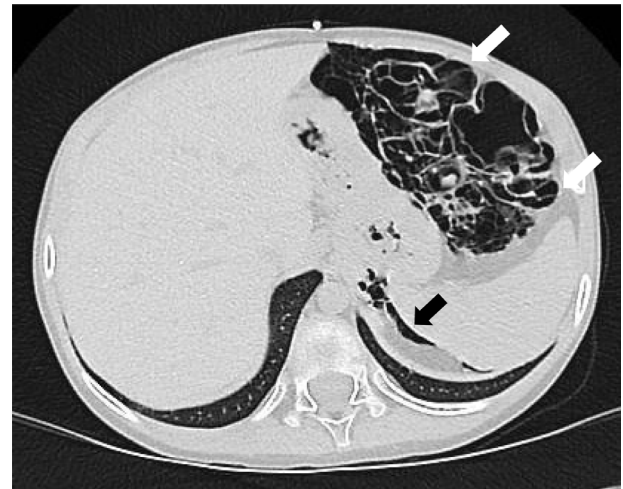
CT scan of the thorax. Axial view in lung window demonstrating free subphrenic air (black arrow) and massive pneumatosis intestinalis of the transverse colon and splenic flexure (white arrow).
